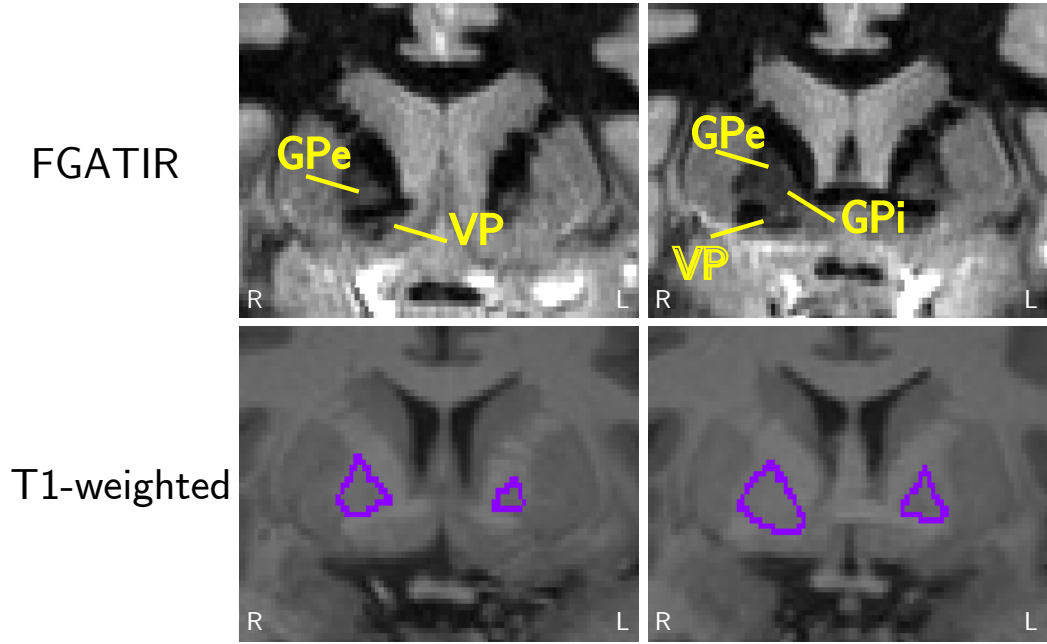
Figure shows the FGATIR image and the T1-weighted image in the same subject. First row is the FGATIR MRI image showing the 3 structural subdivisions of the pallidum, GP_e , GP_i , and VP. The bottom row shows the pallidum ROI (purple) overlaid on the subjects' T1-weighted image. R=right; L=left.
